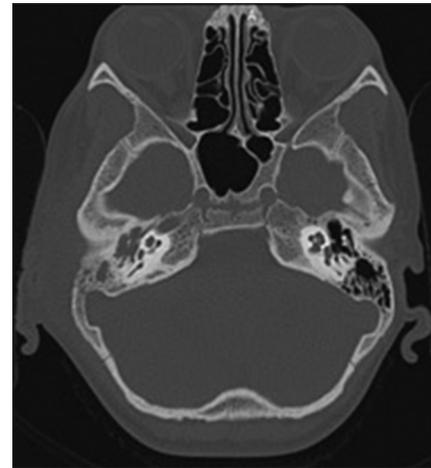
Axial HRCT image showing soft tissue density mass in the right middle ear cavity along with partial erosion of malleus and incus
